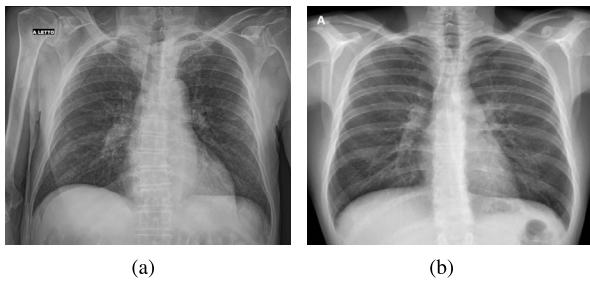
X-ray images of patients who are COVID-19 positive or suspicious [118].
